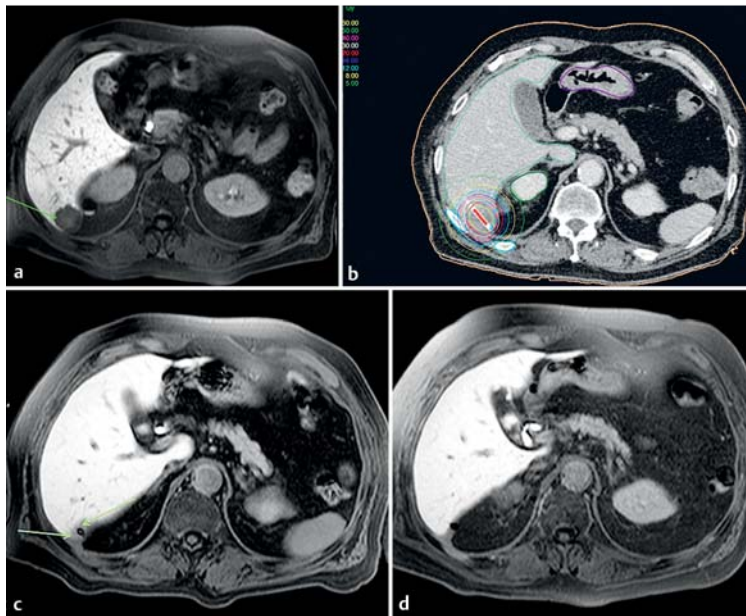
Brachytherapie. a Patient mit hepatisch metastasiertem Sigmakarzinom. Das präinterventionelle MRT mit leberspezifischem Kontrastmittel zeigt eine Lebermetastase im Segment VI. b Planungs-CT mit Einlage eines Brachytheriekatheters. Um den Katheter sind die Isodosen der Bestrahlungsplanung eingezeichnet. Es wurden tumorumschließend 20Gy (rote Linie) appliziert. c MRT 5 Monate nach Brachytherapie: Remission der Lebermetastase im Segment VI. Strahleninduzierter Funktionsausfall des umgebenden Leberparenchyms, Pfeile kennzeichnen ein Speicherdefizit in der Spätphase nach Applikation von hepatozytenspezifischem Kontrastmittel. d MRT 2 Jahre nach Brachytherapie: Anhaltende Remission. Regeneriertes Leberparenchym ohne nachweisbaren Funktionsausfall (regelrechte Speicherung des hepatozytenspezifischen Kontrastmittels).
